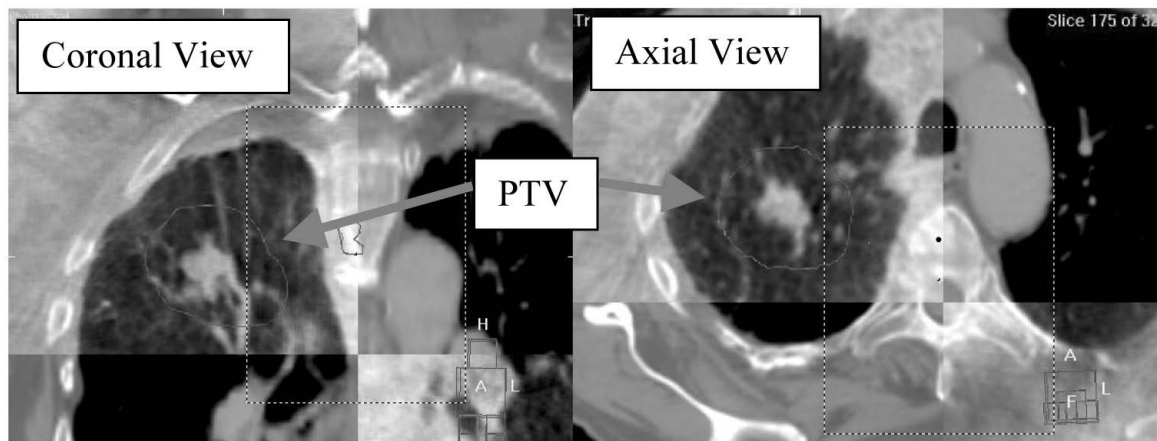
A Checkerboard Display of Image Registration Between a Cone Beam and Reference CT Image Sets for the Lung Lesion. Image of CBCT is Slightly Fuzzier than Reference CT Image. However, it Clearly Shows that the Tumor is Within the PTV
